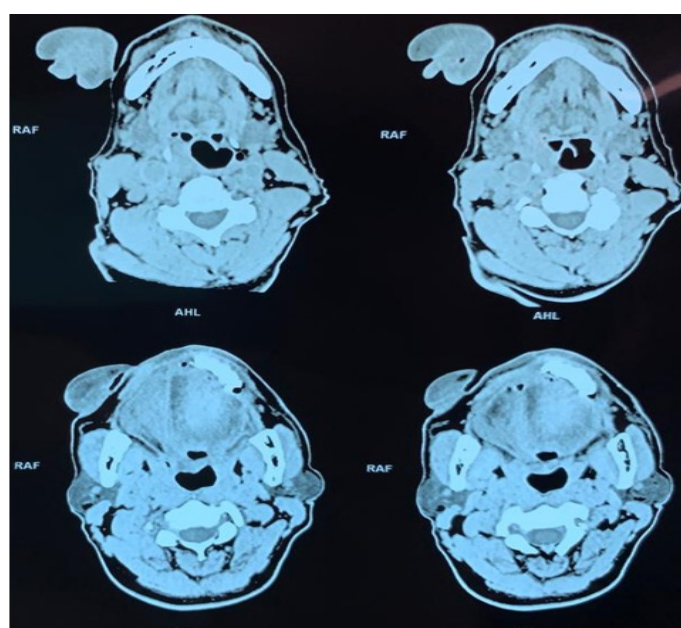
CT image of lipoma of the floor of the mouth
